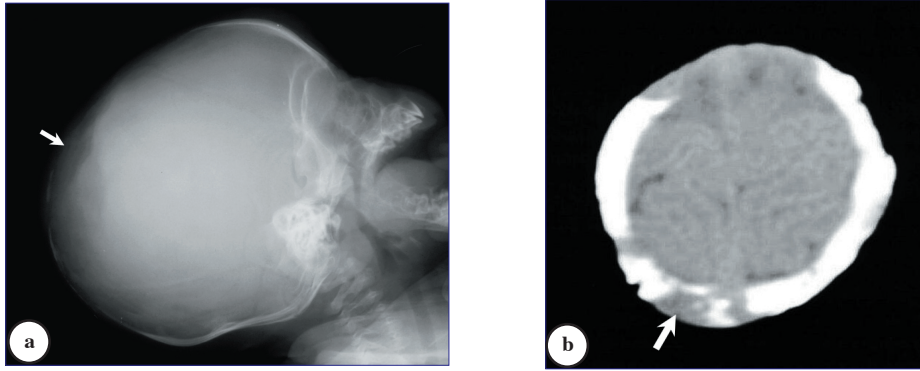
a) Skull radiograph showing calvarial defect over the vertex (arrow). b) Cranial CT scan delineating the skull defect (arrow).
